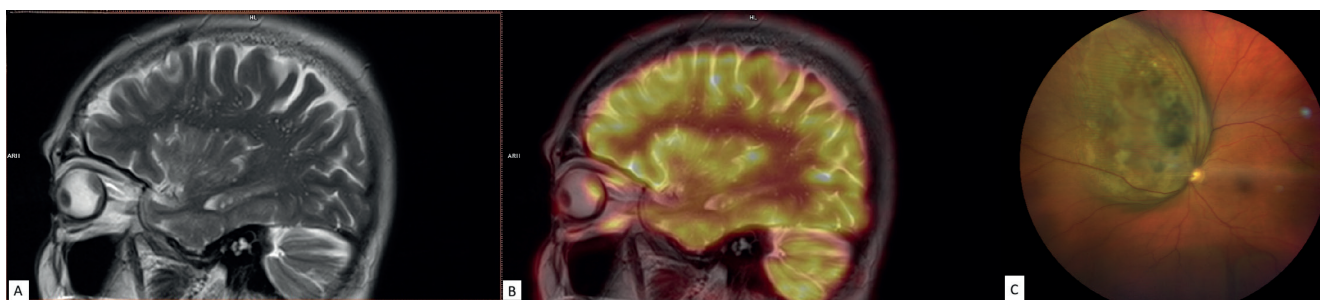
Images of a female patient with choroidal melanoma of the left eye (SUVmax = 14.1). (A) Magnetic resonance imaging. (B) Positron emission tomography showing increased uptake of ^{18}F -fluorodeoxyglucose within the lesion. (C) Fundus photograph demonstrating a large melanoma located at the posterior pole of the left eye
